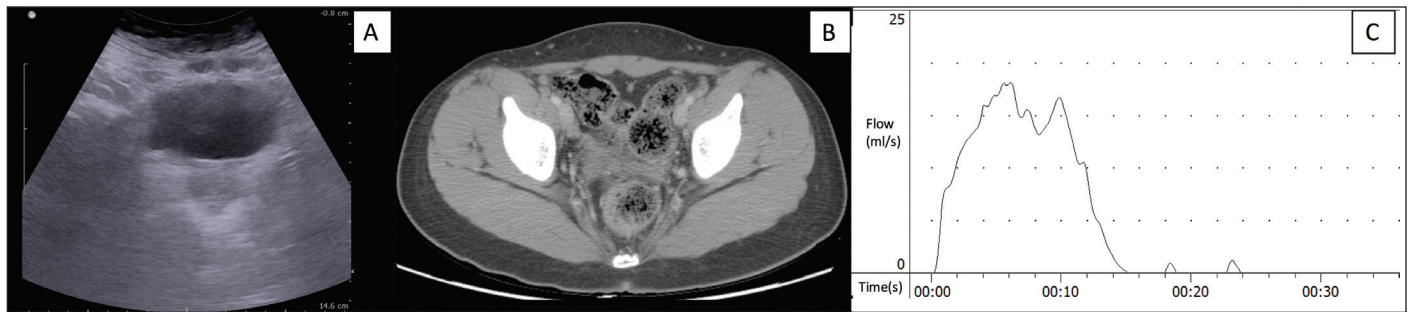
(A & B) Abdominal sonography and contrast-enhanced computed tomography scan of the abdomen and pelvis revealed almost complete resolution of the disease. (C) Uroflow revealed bell-shaped curve.
